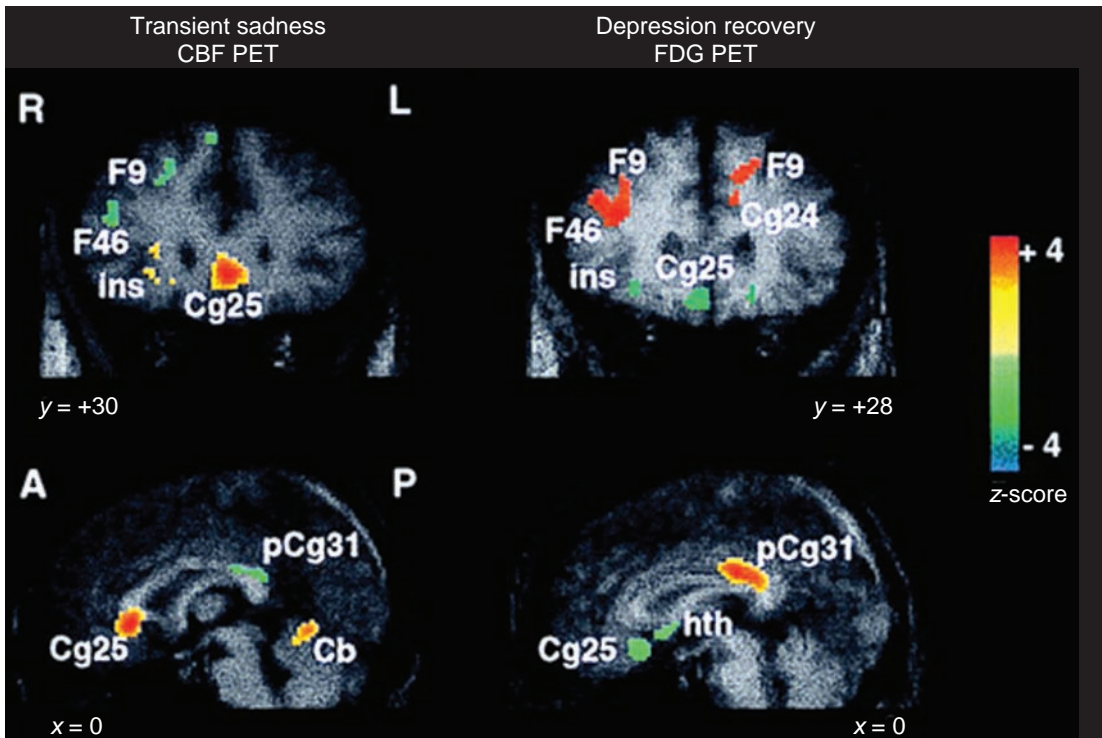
Changes in glucose metabolism and regional cerebral blood flow (as assessed by PET) associated with recovery from major depression and transient sadness in healthy control subjects.⁶ The left-hand images display changes in regional cerebral blood flow with $H_2^{15}O$ -PET associated with transient sadness in eight healthy volunteers (coronal image top, sagittal view bottom). The right-hand images show changes in regional glucose metabolism with FDG-PET after 6 weeks of fluoxetine treatment in eight unipolar depressed patients. Sadness is associated with increases in ventral paralimbic regions and decreases in dorsal frontal regions. With recovery from depression, the reverse is seen: ventral decreases and dorsal cortical increases. Slice locations are shown in millimeters relative to the anterior commissure. Numbers are Brodmann area designations. R, right; L, left; A, anterior; P, posterior; F, prefrontal; ins, anterior insula; Cg24, dorsal anterior cingulate; Cg25, subgenual cingulate; pCg, posterior cingulate; Cb, cerebellum; hth, hypothalamus. Color scale: red indicates increases and green indicates decreases in flow or metabolism.
